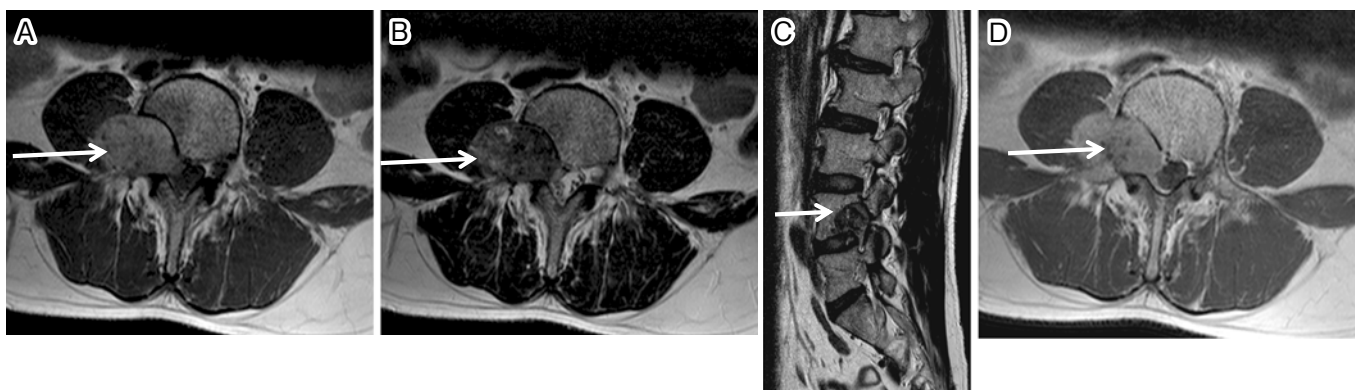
Magnetic resonance imaging (MRI) reveals a tumor with high T1-weighted and low T2-weighted signal intensities and homogenous gadolinium enhancement. (A) T1-weighted axial image, (B) T2-weighted axial image, (C) T2-weighted sagittal image, and (D) gadolinium enhanced T1-weighted axial image.
